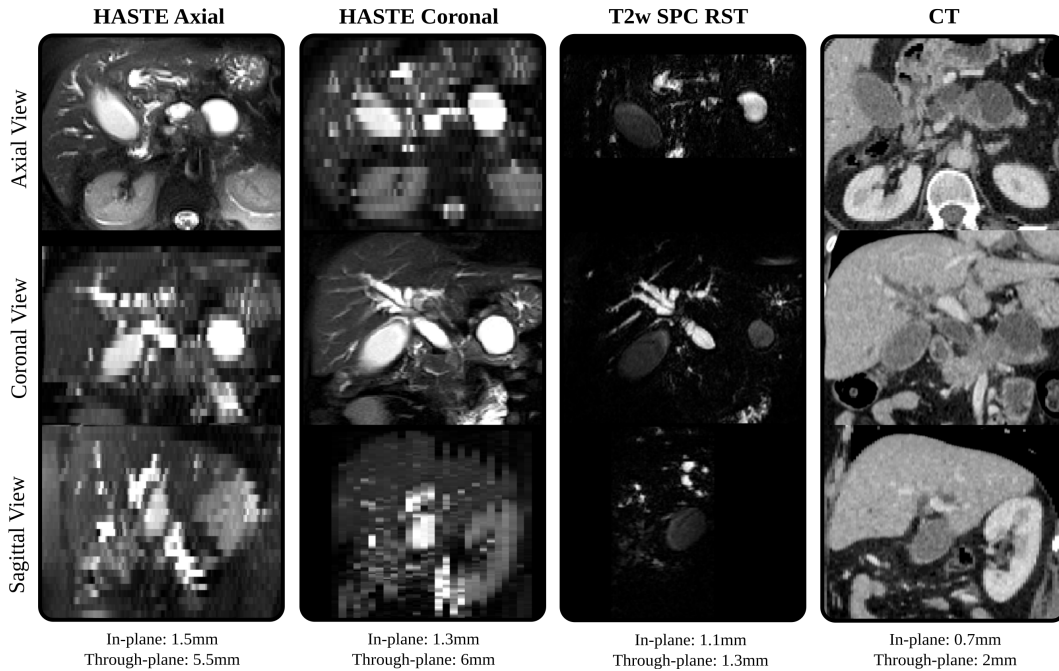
Visualization of typical MR data in MRCP studies showing the anatomy of the biliary tree acquired at 1.5 T (Image adapted from [Ebner et al., 2017a]). Motion is visible throughout the HASTE stacks. The heavily T2-weighted volume (T2w SPC RST) has approximately five times higher resolution compared to the HASTE through-plane direction. However, the heavily T2-weighted volume loses valuable tissue contrast in the surrounding anatomy. Additionally acquired contrast-enhanced computed tomography (CT) image allows assessment in high resolution but does not have the inherent high soft tissue contrast of MRI and carries the risk of radiation exposure, iodinated contrast exposure and toxicity of kidneys.
